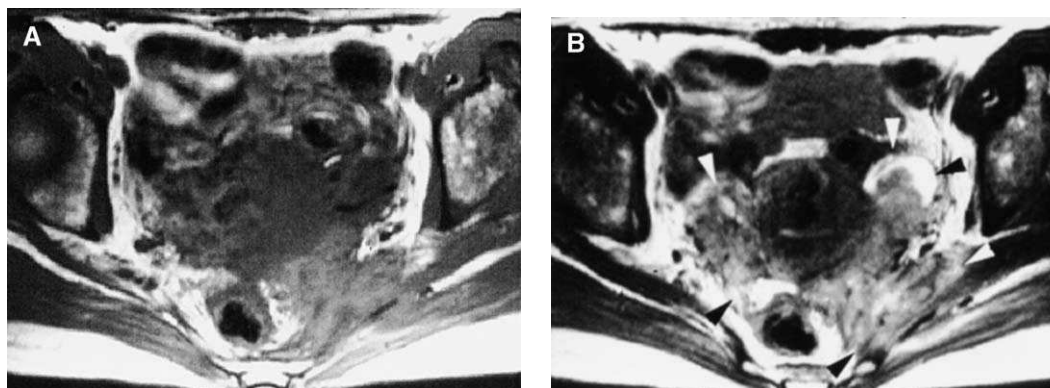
Pelvic actinomycosis. (A) T1-weighted image shows a lesion that involves bilateral adnexa, the uterus, and left piriform muscle. This pattern of extension is called transfascial extension. (B) T2-weighted image reveals a predominantly solid mass of relatively low signal intensity with a small cystic component (arrowheads).
